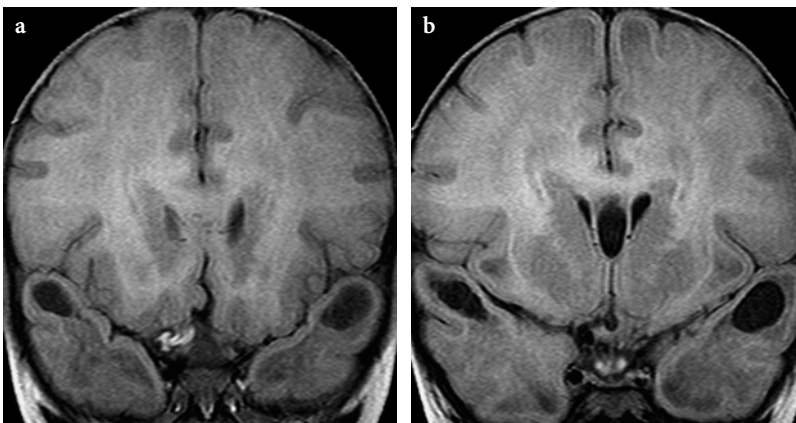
Subcortical cysts in van der Knaap disease (same patient as in Fig. 13.112). a, b Coronal FLAIR images. The subcortical cysts within the superior temporal gyri, which are hardly conspicuous on T2- and T1-weighted images, are clearly demonstrated with this technique
